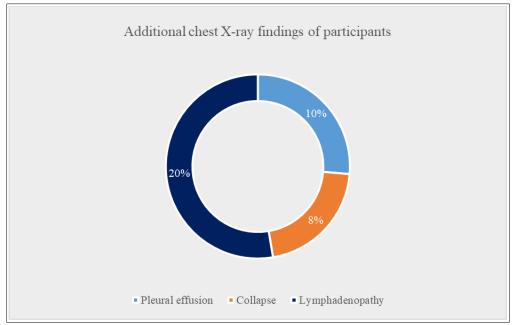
Ring chart showed additional chest X-ray findings of the participants (N=100)
